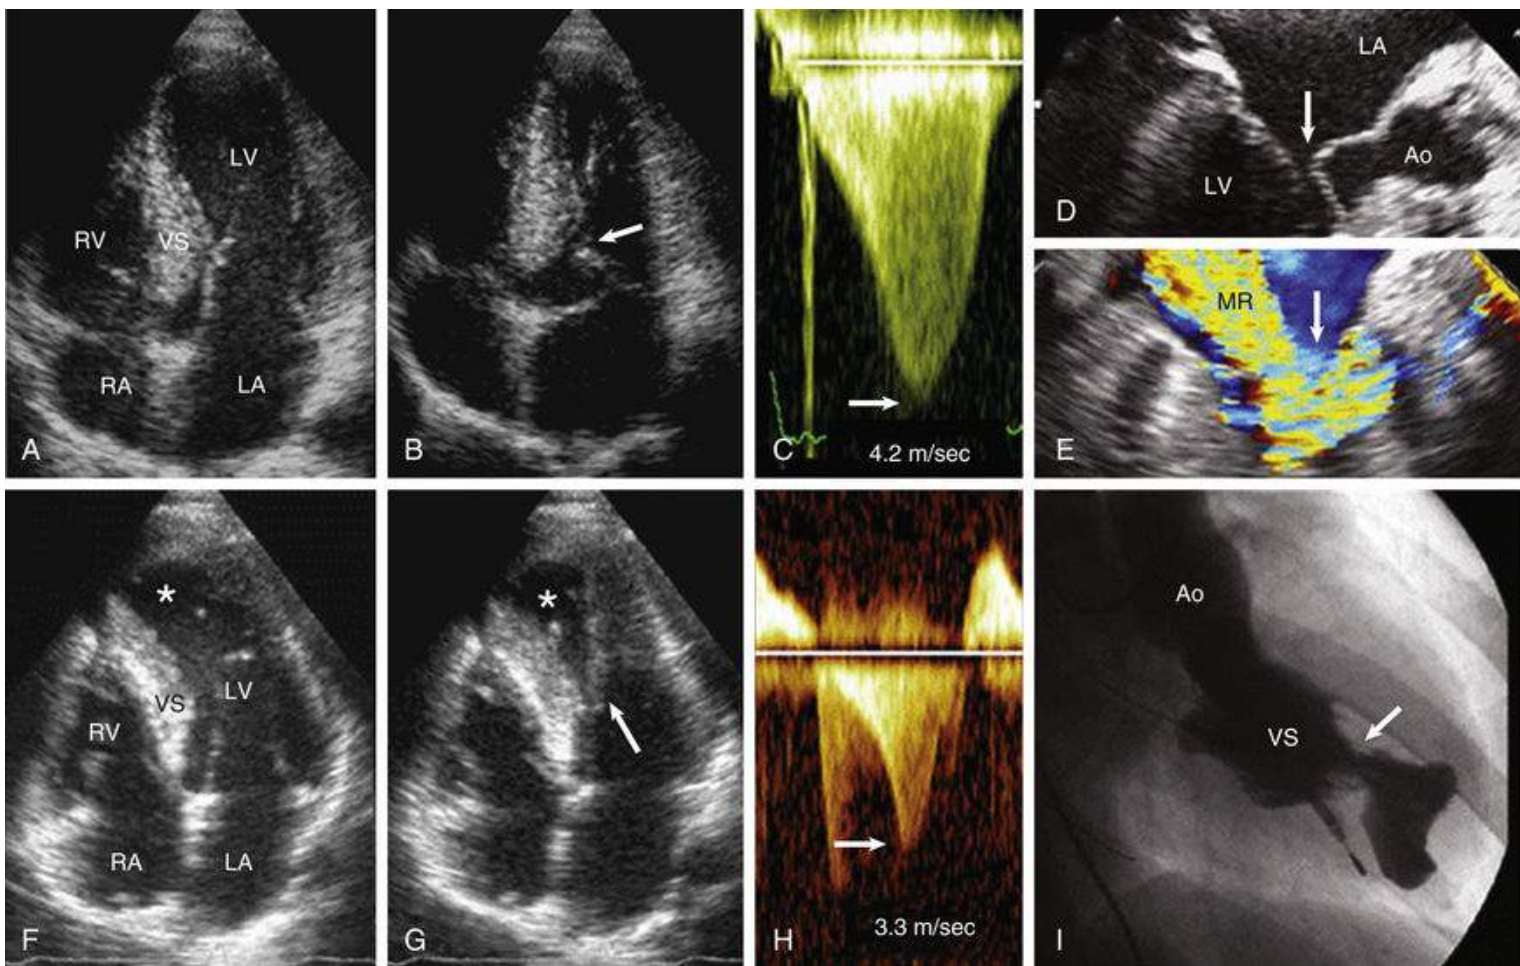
Dynamic LV outflow obstruction. A to E, Subaortic obstruction due to systolic anterior motion (SAM) of the mitral valve. Echocardiographic apical four-chamber view at (A) end-diastole and at (B) end-systole as the anterior mitral leaflet bends acutely with septal contact (*arrow*). C, Continuous-wave (CW) Doppler interrogation of the LV outflow tract showing the typical late-peaking waveform, with velocity of 4.2 m/s in midsystole, estimating a gradient of 70 mm Hg (*arrow*). D and E, transesophageal echo plane showing incomplete mitral leaflet coaptation during SAM (*arrow*), producing posteriorly directed mitral regurgitation (MR) jet. F to I, Midventricular obstruction. Echocardiographic apical four-chamber view at end-diastole (F) and end-systole, showing hypertrophied anterolateral papillary muscle appearing to insert directly into anterior mitral leaflet, creating midventricular muscular obstruction (G) (*arrow*). H, CW Doppler interrogation of LV outflow tract showing late-peaking waveform with peak velocity of 3.3 m/s, estimating a gradient of 45 mm Hg (*arrow*). I, LV ventriculogram showing hourglass contour of chamber associated with midventricular obstruction (*arrow*). Ao, aorta; LA, left atrium; LV, left ventricular; MR, mitral regurgitation; RA, right atrium; RV, right ventricle; VS, ventricular septum. (From Yacoub MH, El-Hamamy I, Said K, et al. The left ventricular outflow in hypertrophic cardiomyopathy: from structure to function. *J Cardiovasc Transl Res* 2009;2:510-517; Olivetto I, Girolami F, Nistri S, et al. The many faces of hypertrophic cardiomyopathy: from developmental biology to clinical practice. *J Cardiovasc Transl Res* 2009;2:349-67.)
